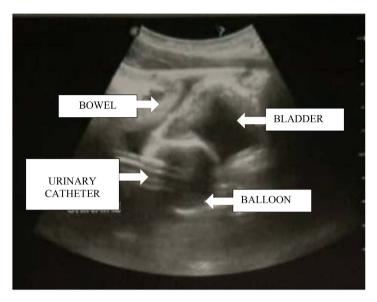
Abdominal and pelvic ultrasound.
